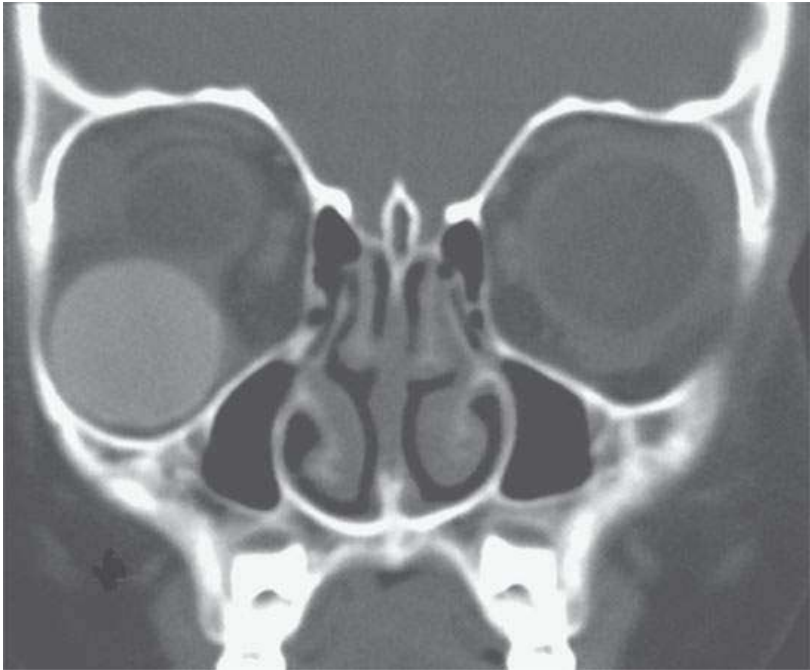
Computed tomography (CT) of a dermoid cyst of the orbit that is high density compared to muscle—a fairly atypical finding even in these developmental cysts as they are seen on CT.
